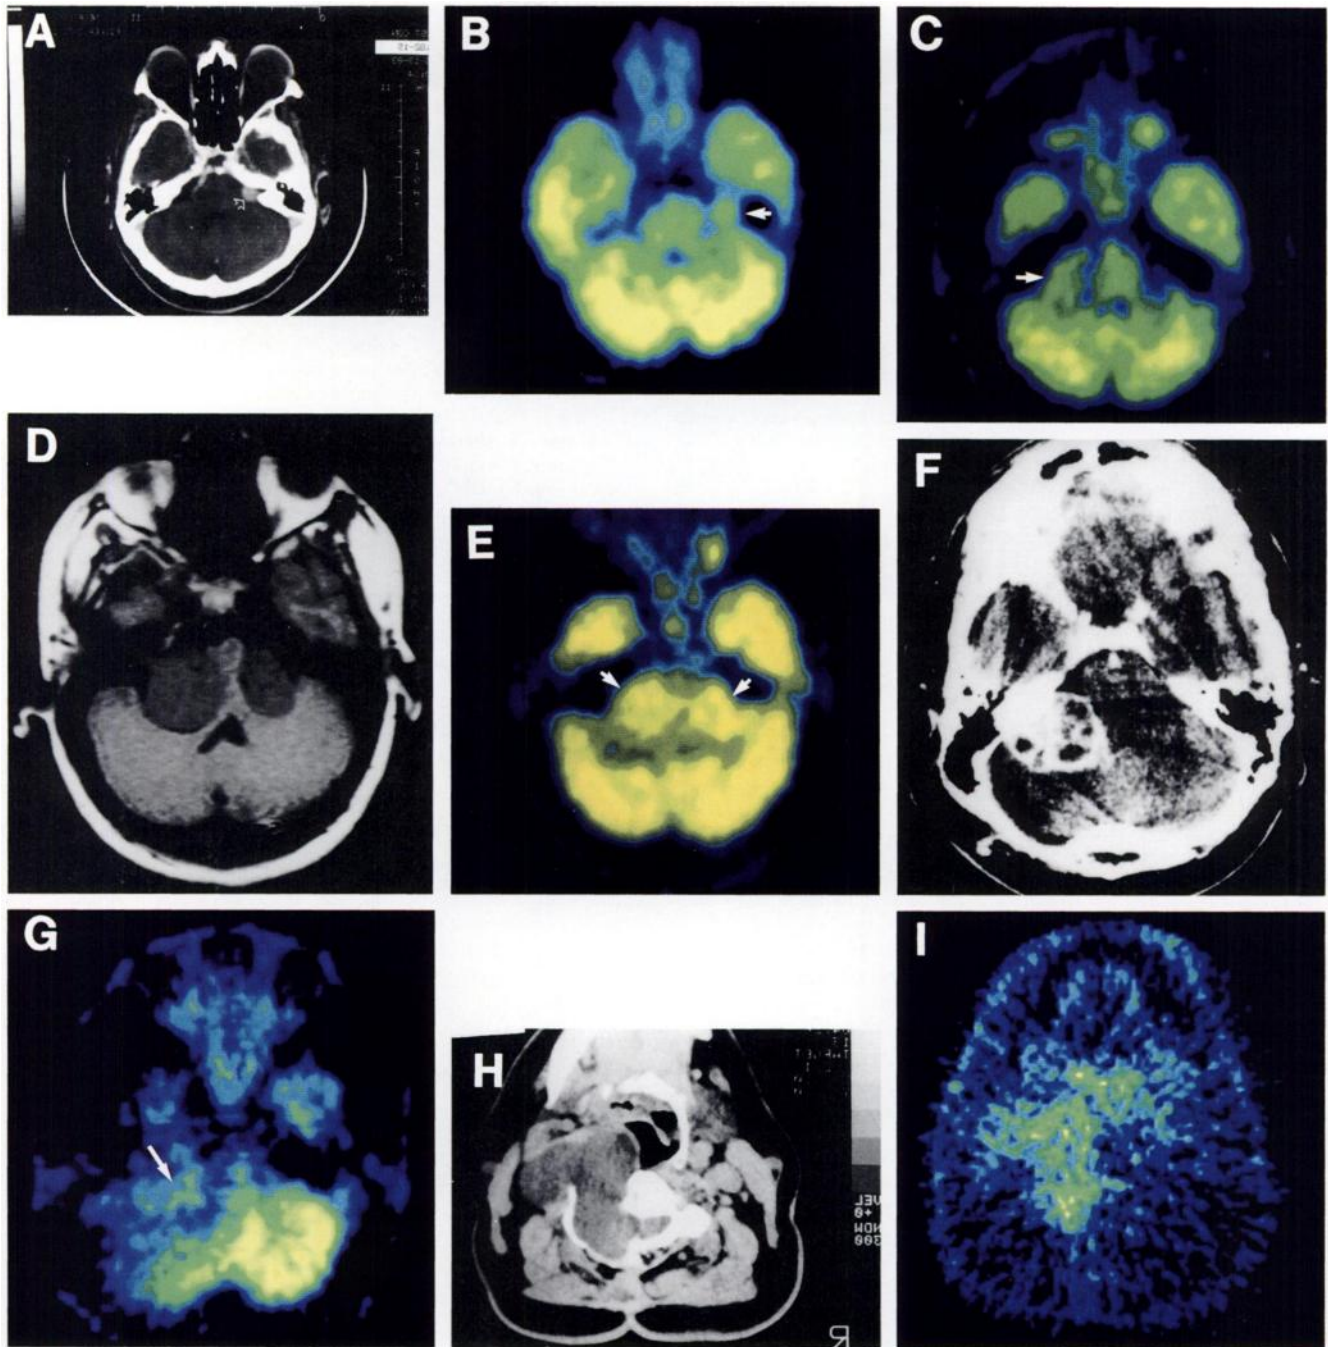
(A) Patient 1. A 72-yr-old woman with a 2-yr history of profound right hearing loss and vertigo of recent onset. Postcontrast CT scan shows a rounded, enhancing lesion (open arrow) in the right cerebellopontine angle (CPA). (B) PET-FDG shows a circumscribed focus of increased glucose utilization (arrow) closely corresponding to the tumoral mass in the CT study. (In all CT, MRI, and PET images, the laterality is consistent: right of patient on right of viewer.) (C) Patient 2. A 68-yr-old man with a 5-mo history of left hearing loss and tinnitus. The PET-FDG scan shows an ovoid, circumscribed focus of increased glucose utilization in the left CPA (arrow). CT studies (not shown) demonstrated a 3.5-cm solid, contrast-enhancing left CPA lesion. (D) Patient 3. An 18-yr-old woman with a 10-yr history of neurofibromatosis Type 2. MRI scan shows bilateral CPA mass lesions (L > R). The mass on the left extends into the internal auditory meatus and compresses the fourth ventricle, and both masses compress the brainstem. (E) PET-FDG shows areas of increased glucose utilization (arrows) corresponding to the tumors shown in (D). The tumoral rate of glucose utilization approaches that of the cerebellar cortex. (F) Patient 6. A 38-yr-old man with a 3-yr history of hoarseness and weakness of elevation of left shoulder. Surgery was performed on two occasions (1 and 3 years before PET) with partial removal of a left 9th neuroma. Postcontrast CT shows a heterogeneously enhancing mass in the lateral aspect of the left posterior fossa. The left cerebellar hemisphere is compressed. (G) On PET-FDG of Patient 6, the tumoral metabolism (arrow) contrasts with surrounding hypometabolism, which is probably related to previous surgery and radiotherapy. (H) Patient 7. A 68-yr-old man with a 13-yr history of neck mass (neuronal) which was partially resected in 1971. He had noted increasing weakness and numbness in the left side as well as a change in voice over a 4-mo period. Postscontrast CT shows a large mass eroding the left body and arch of the C3 vertebra and extending into the hypopharynx and soft tissues of the neck. (I) PET-FDG of Patient 7. Note striking correspondence between increased glucose utilization in the cervical soft tissues and the mass demonstrated on the CT scan.
